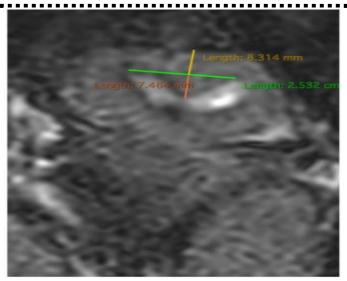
Coronal T2FS MR image showing the uterine wall thickness in yellow- measuring approximately 8.3 mm and internal indentation in orange measuring approximately 7.4 mm. Thus, according to ASRM criteria, the internal indentation is less than 1 cm and therefore this is a normal/Arcuate uterus. However, according to ESHRE-ESGE classification, the internal indentation is more than 50% uterine wall thickness and therefore, this falls under the category of partial Septate uterus.
